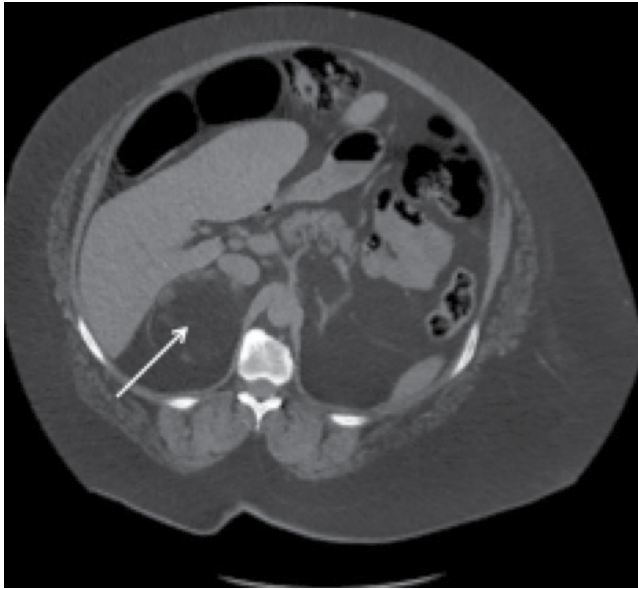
A 55-year-old female with 7.7 cm fat—containing right adrenal mass (arrow) on noncontrast CT of the abdomen. Surgical pathology consistent for myelolipoma.
